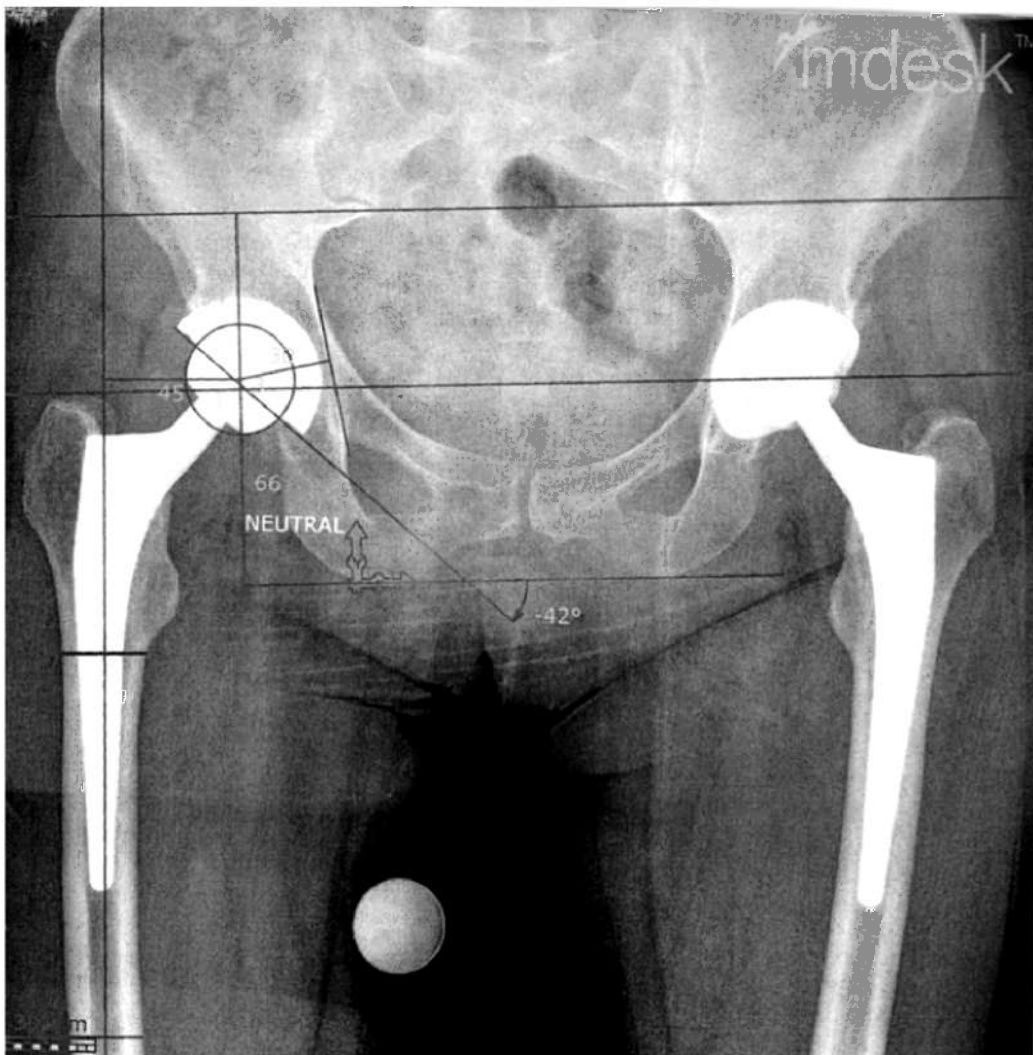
An X-ray and different reference points and measured distances using M-desk
